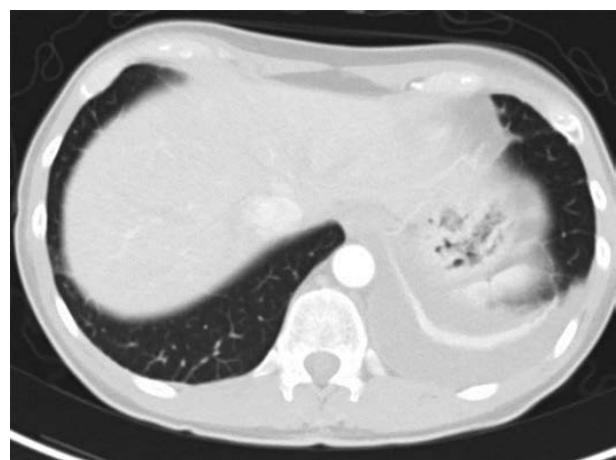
CT scan from a patient with mesothelioma demonstrating a mass in the left lung, a pleural effusion, pleural thickening, and a shrunken hemithorax.
